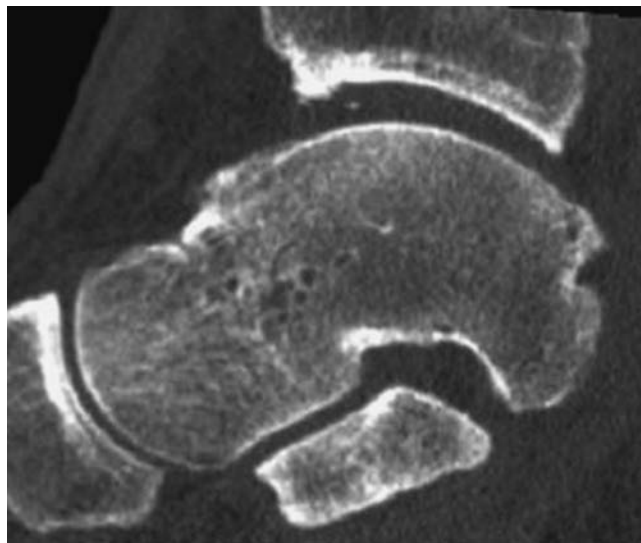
A preoperative computed tomography (CT) scan with sagittal image reconstructions is important to determine the size and location of posterior located osteochondral defects. A sagittal CT reconstruction of a left ankle with an osteochondral defect that is located at the posterior end of the talar dome.
